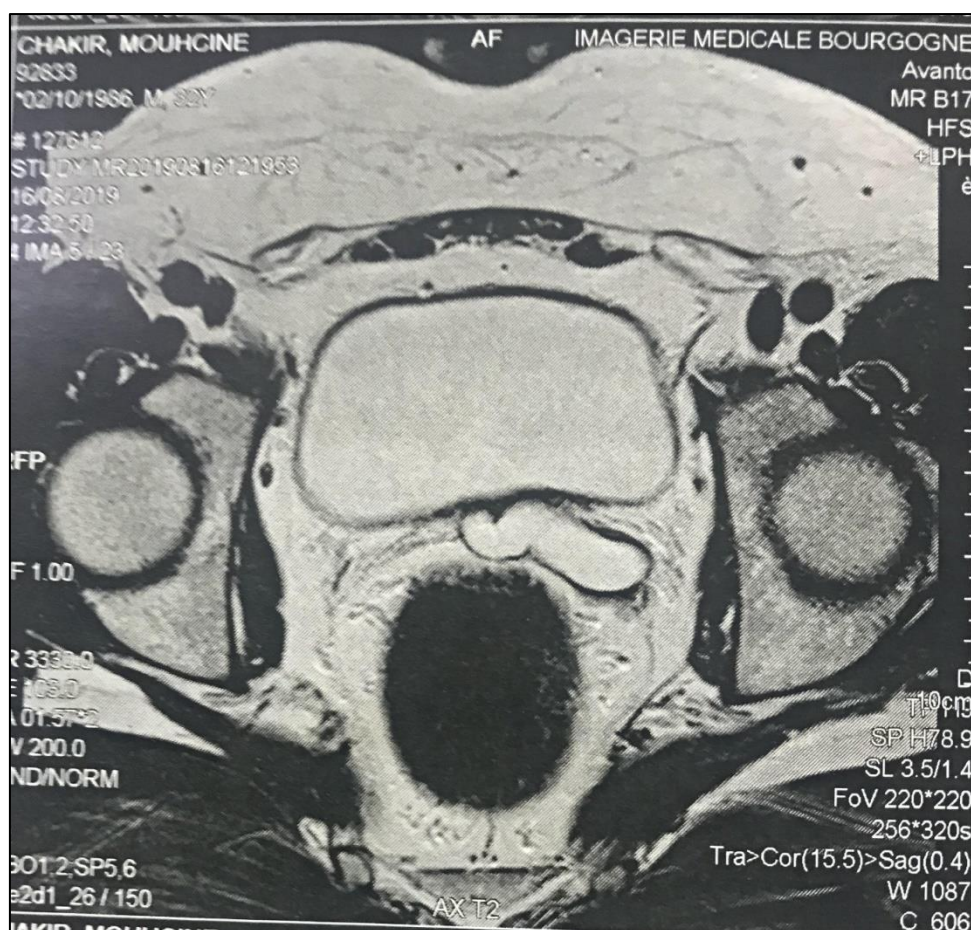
Magnetic resonance imaging of the deep seminal tract in coronal section in T2 sequence. Demonstration of the prostate. Absence of visualization of the right seminal vesicle with distension of the left seminal vesicle most probably related to stenosis of its terminal portion
